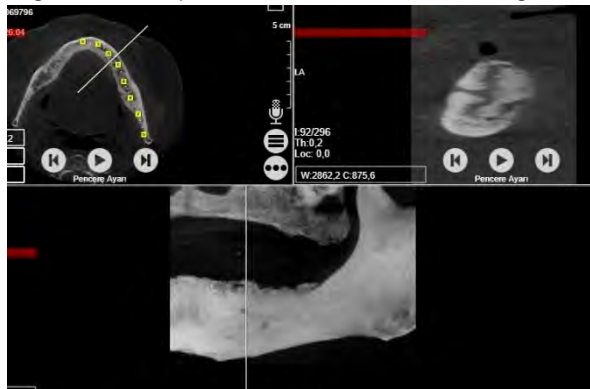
Preoperative computed tomography (CT) image
